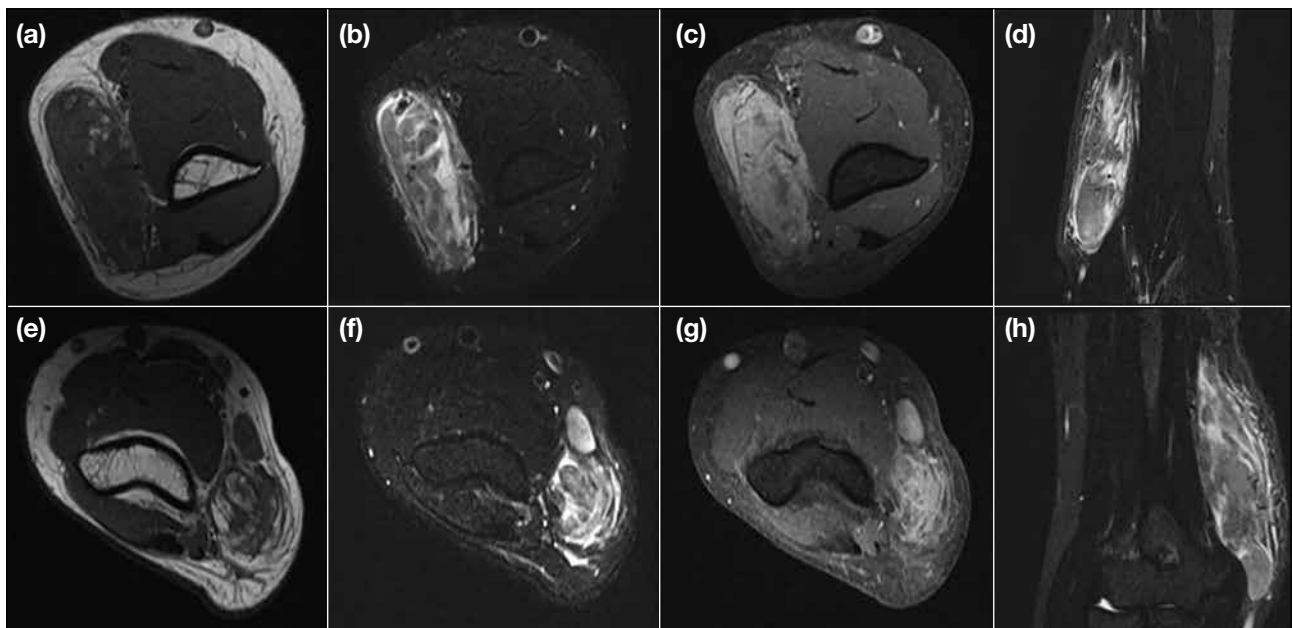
Magnetic resonance imaging of (a-d) left elbow and (e-h) right elbow in case 1. (a) Ill-defined subcutaneous mass with intermediate signal on axial T1-weighted image. (b) Heterogenous intermediate signal on axial T2-weighted fat suppressed image with encasement of basilic vein and internal flow voids. (c) Moderate homogeneous enhancement on axial T1-weighted fat suppressed image with contrast. (d) Medial epitrochlear location with mild adjacent subcutaneous oedema and strandings on coronal T2-weighted short tau inversion recovery image. (e-h) Similar findings at right elbow with additional discrete enlarged oval lymph node.
